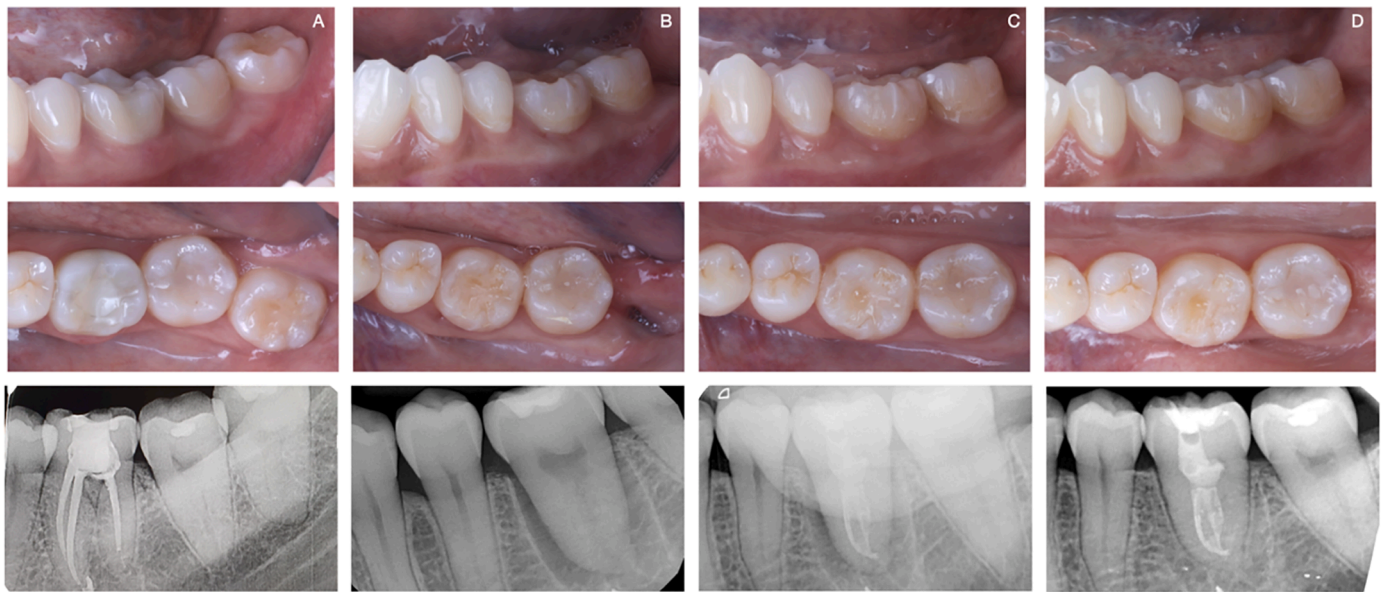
Clinical and radiographic evolution of a study case.
